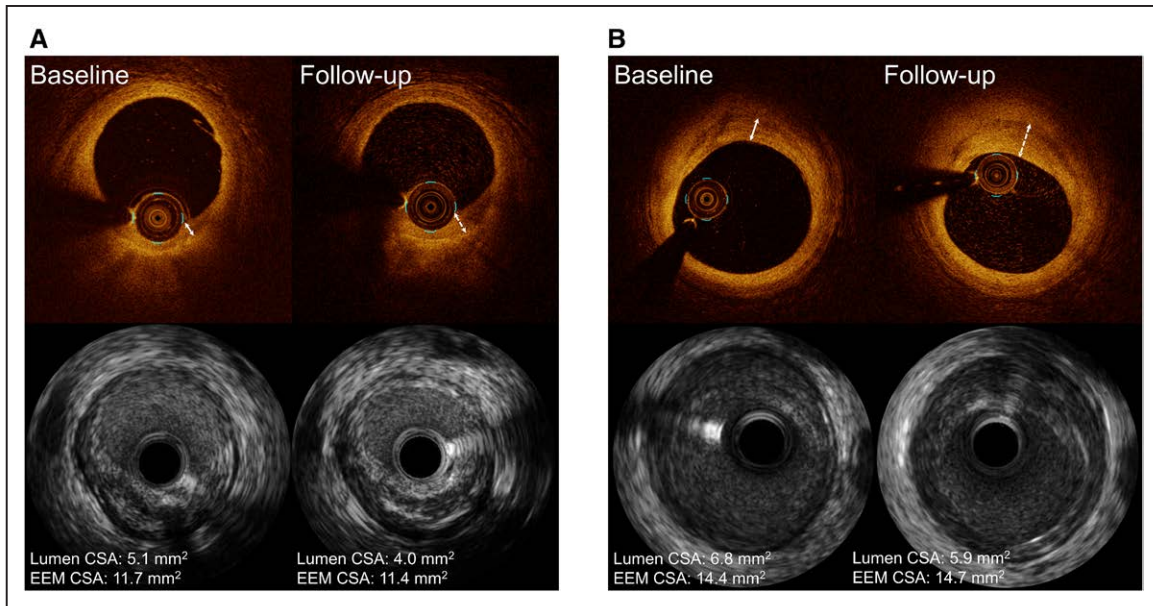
Representative cases of type II lesion progression. A, Case 1: optical coherence tomography (OCT; top) shows a layered pattern (double-headed arrow) at baseline, characterized as the most superficial region that showed different optical intensity from underlying plaque. At 8-month follow-up, the layer increased in thickness (dotted double-headed arrow). B, Case 2: OCT shows a layered pattern (double-headed arrow) at baseline. At 8-month follow-up, the layer increased in thickness (dotted double-headed arrow). Corresponding intravascular ultrasound cross-sections (bottom) show progression (>0.5 mm² decreased in lumen area). CSA indicates cross-sectional area; and EEM, external elastic membrane.
